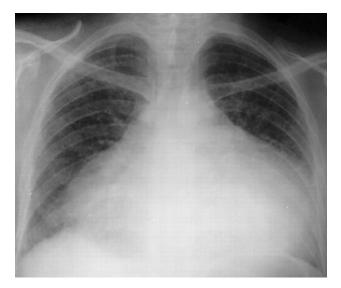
A chest radiograph of cardiac tamponade. This patient requires immediate treatment with a pericardiocentesis, which can be done at the bedside in a life-threatening situation. © Santibhavank P/Shutterstock.
